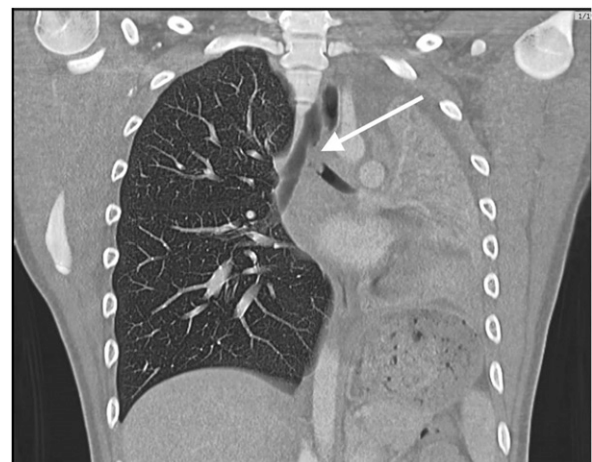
Computed tomographic scan of the chest revealing a filling defect in the left mainstem bronchus, collapse of the left lung, and compensatory hyperinflation of the right lung.
